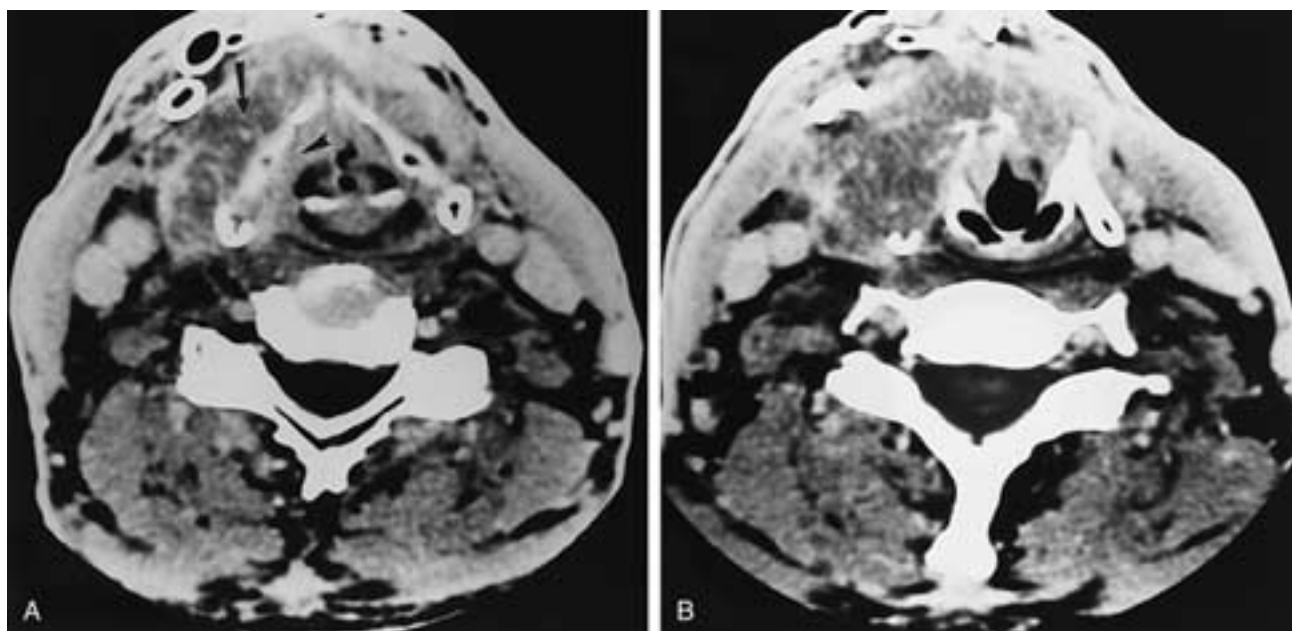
Axial CT scans. A, Infection of the soft tissues of the neck showing obscuration of the fat planes (*arrow*) and extension into the paraglottic fat of the larynx (*arrowhead*). The drains in the neck are from decompression of an abscess. B, Level of the cricoid showing considerable soft-tissue thickening impinging on the airway.
